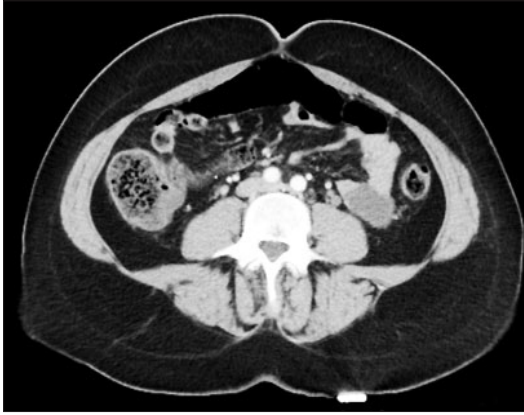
Contrast-enhanced computed tomography of the abdomen, showing parietal wall thickening (initial investigation).
